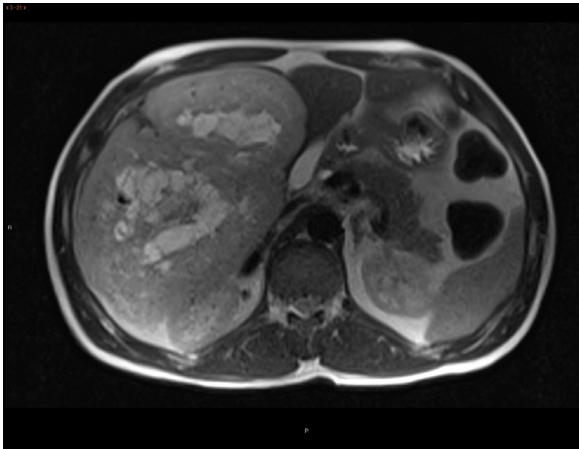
MRI: T2-weighted sequence of the axial plane showing a large well-outlined mass, exophytic, dependent on liver segments V-VI, with a compressive effect on extrahepatic structures yet no apparent infiltration and with an extensively necrotic central area or cystic degeneration.
